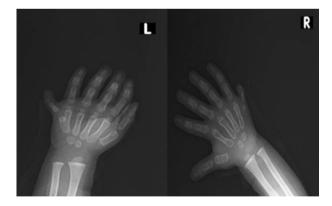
X-ray image of the second case; extra fingers in left and right hands.
